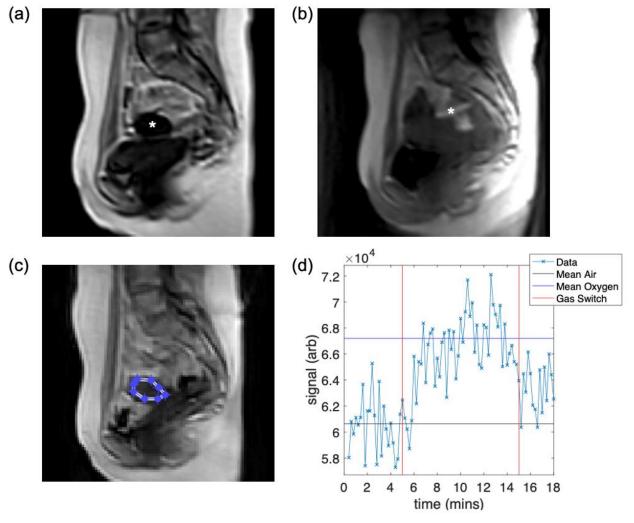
Early examples of healthy volunteer pelvic imaging using OE-MRI sequences in development. Artefact (\*) from areas of signal drop out in (a) and oxygen tubing interposed between participant and the anterior body coil in (b). Initial assessment of the uterine body (c) in a higher quality OE-MRI scan resulted in (d) an arbitrary signal time-series which shows a change in signal following 100% oxygen delivery.
